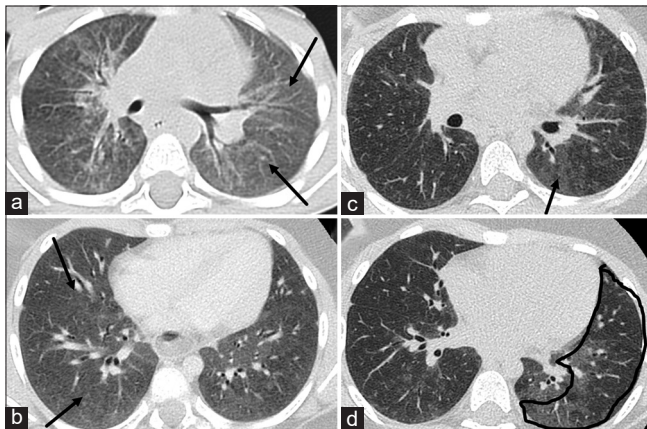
Serial axial computed tomography images through the mid lungs over a span of 7 years in a male with adenine triphosphate-binding cassette transporter protein A3 mutation. a showed extensive ground glass opacities on the initial scan (black arrows). b performed two years later showed slightly improving ground glass opacities in the right lung (black arrows). c performed 5 years later showed continued improving ground glass opacity (black arrow). d performed 7 years later showed persistent air trapping and mosaic attenuation (black outline).
